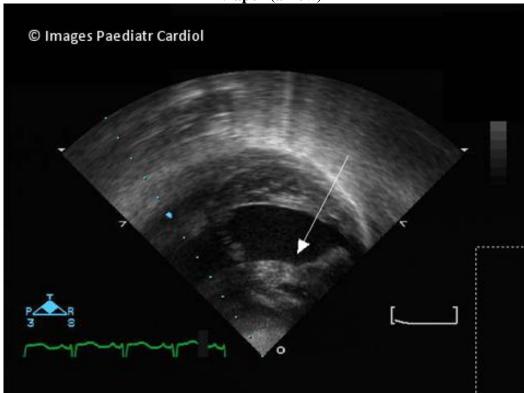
Short axis view, 2 D echocardiogram showing a large LV thrombus in the LV apex (VIDEO)
